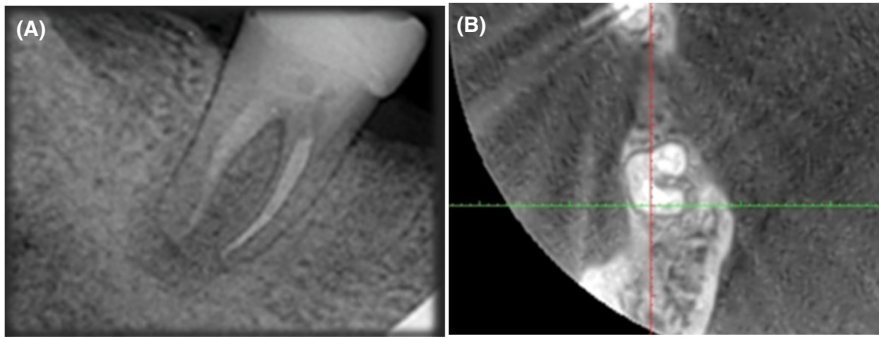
(A) Follow-up radiograph after 6 months. Healing of periradicular lesions is observed. (B) CBCT evaluation after 12 months revealed satisfactory outcome of the treatment.
